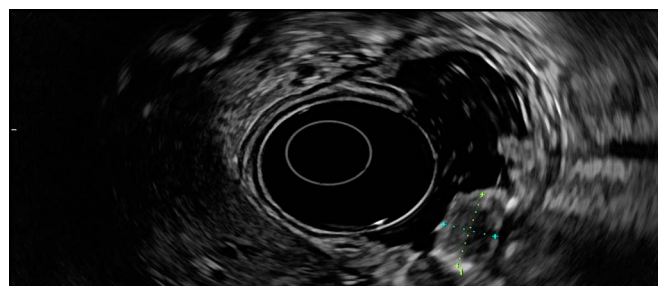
Endoscopic ultrasound demonstrated a 12-mm hypoechoic lesion in the deep mucosa (layer 2).
